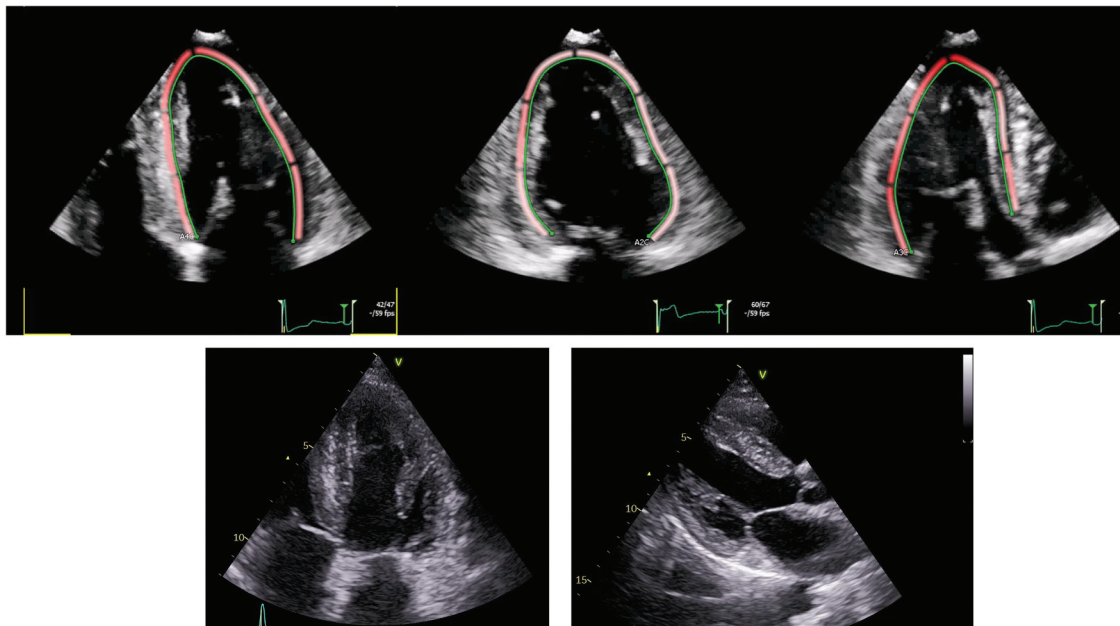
Transthoracic echocardiogram Hypertrophic cardiomyopathy with end-diastolic thickness of around 13 mm and a thickness of valvular leaflets. A scintillating appearance of the myocardium is also shown.
